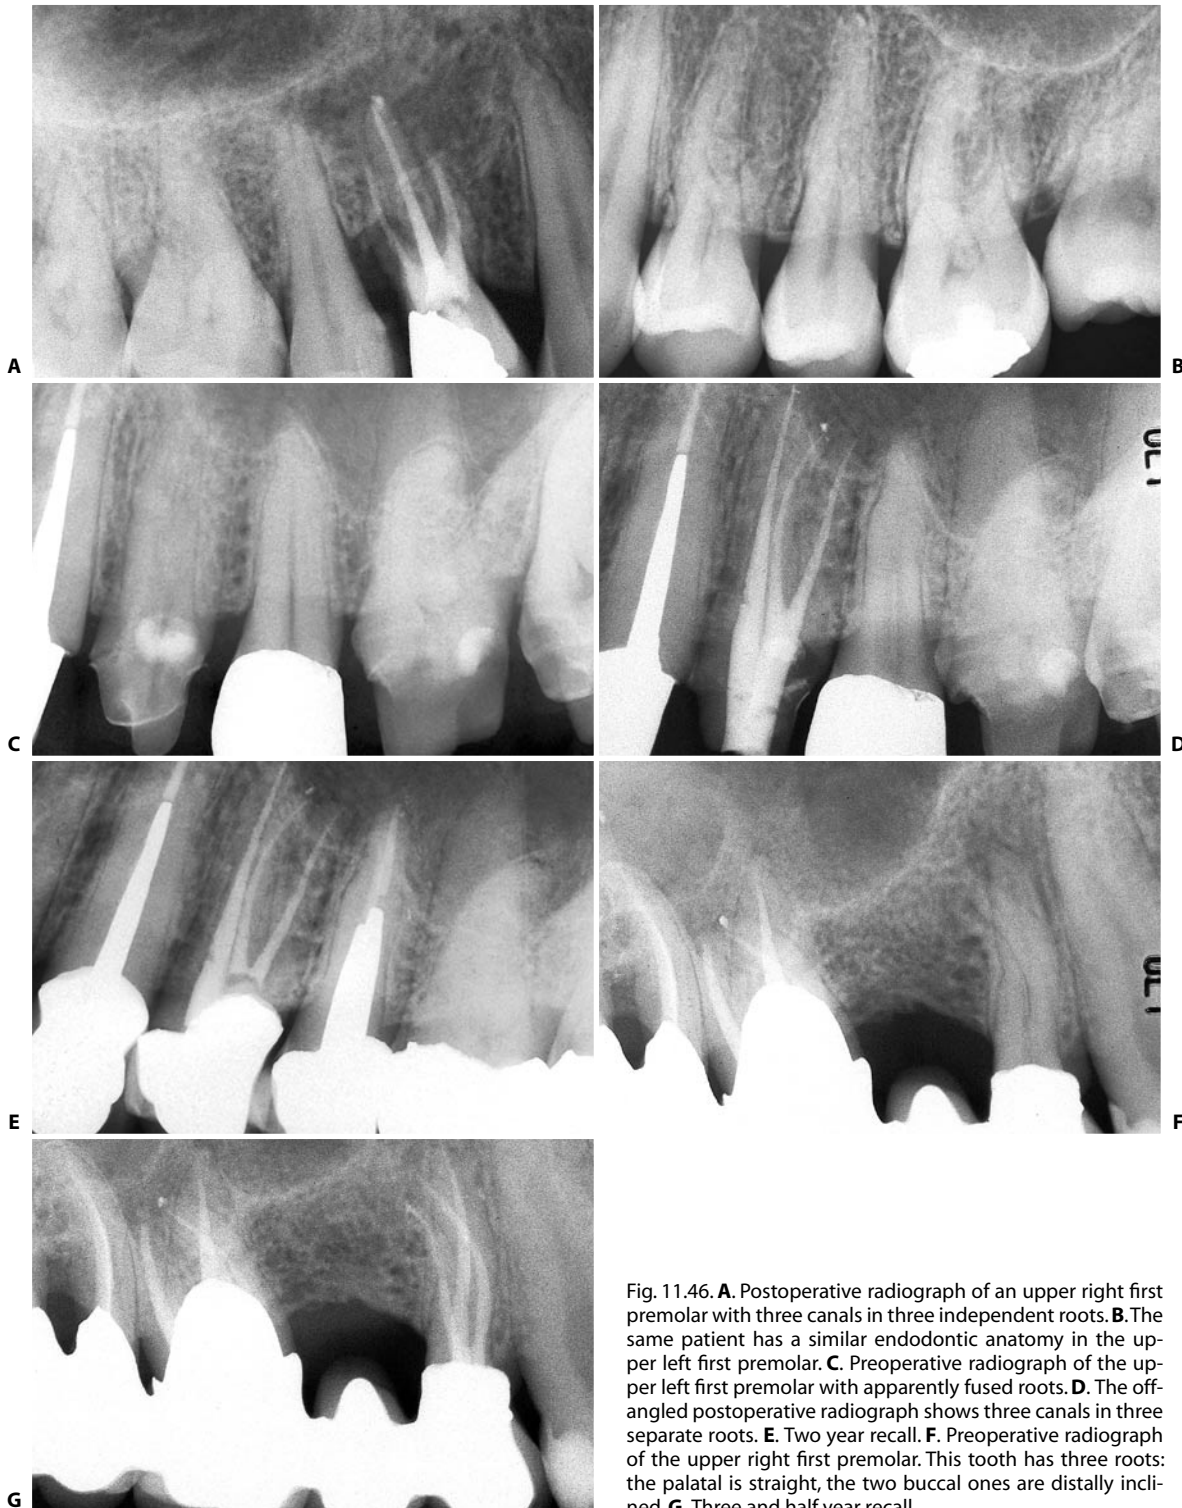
A. Postoperative radiograph of an upper right first premolar with three canals in three independent roots. B. The same patient has a similar endodontic anatomy in the upper left first premolar. C. Preoperative radiograph of the upper left first premolar with apparently fused roots. D. The off-angled postoperative radiograph shows three canals in three separate roots. E. Two year recall. F. Preoperative radiograph of the upper right first premolar. This tooth has three roots: the palatal is straight, the two buccal ones are distally inclined. G. Three and half year recall.
